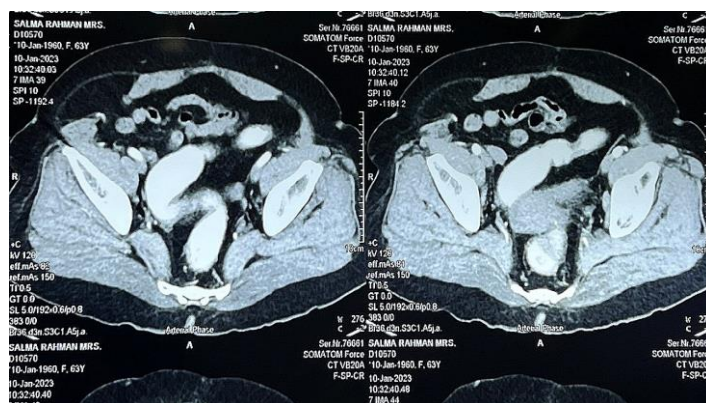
CT scan showing the defect.
